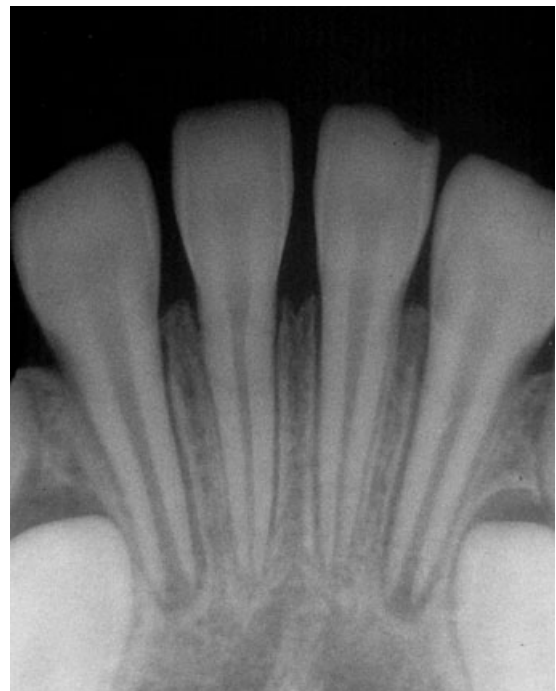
After 2 months, fixation was removed, because the radiograph showed healing of the fractured fragment.
